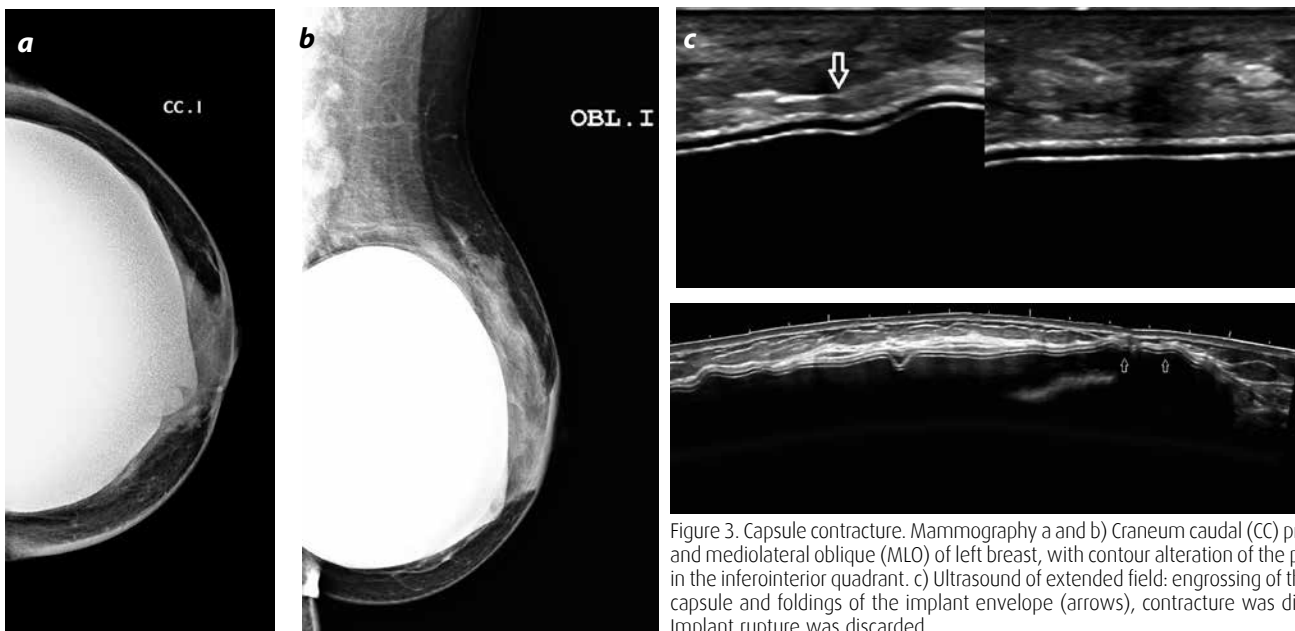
Capsule contracture. Mammography a and b) Craneum caudal (CC) projections and mediolateral oblique (MLO) of left breast, with contour alteration of the prosthesis in the inferointerior quadrant. c) Ultrasound of extended field: engrossing of the fibrous capsule and foldings of the implant envelope (arrows), contracture was diagnosed. Implant rupture was discarded.
